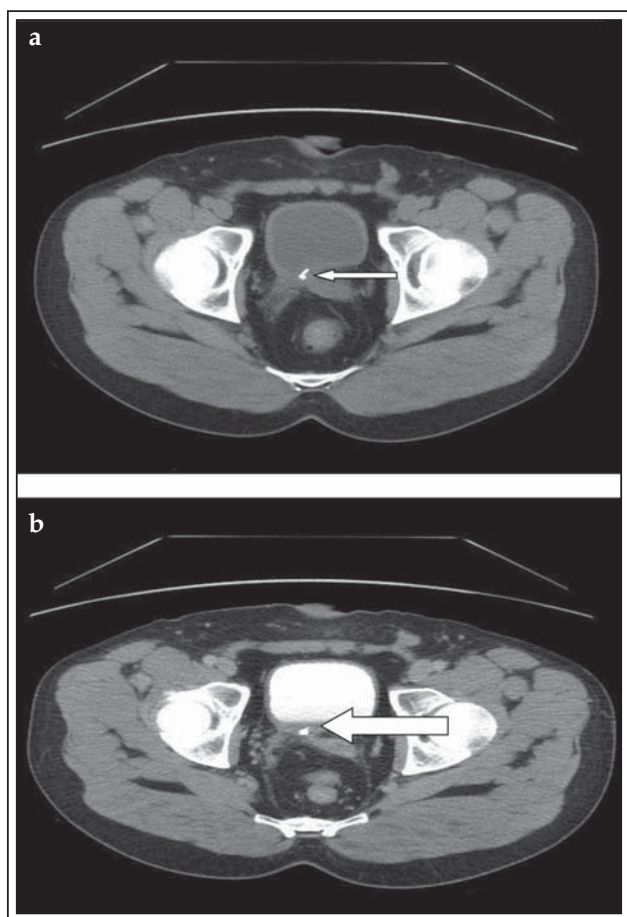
a) Post operative CT urogram arrow showing absent cyst with clip in place, b) in contrast phase with no extravasation.
